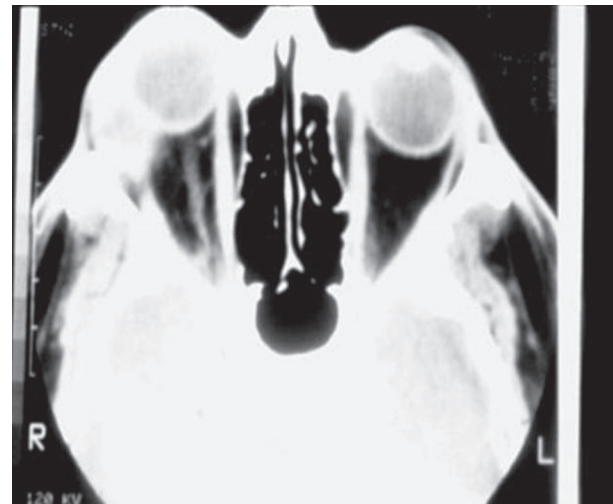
CT orbital image after 4- cycles of chemotherapy 2003y. – tumor mass is declining
